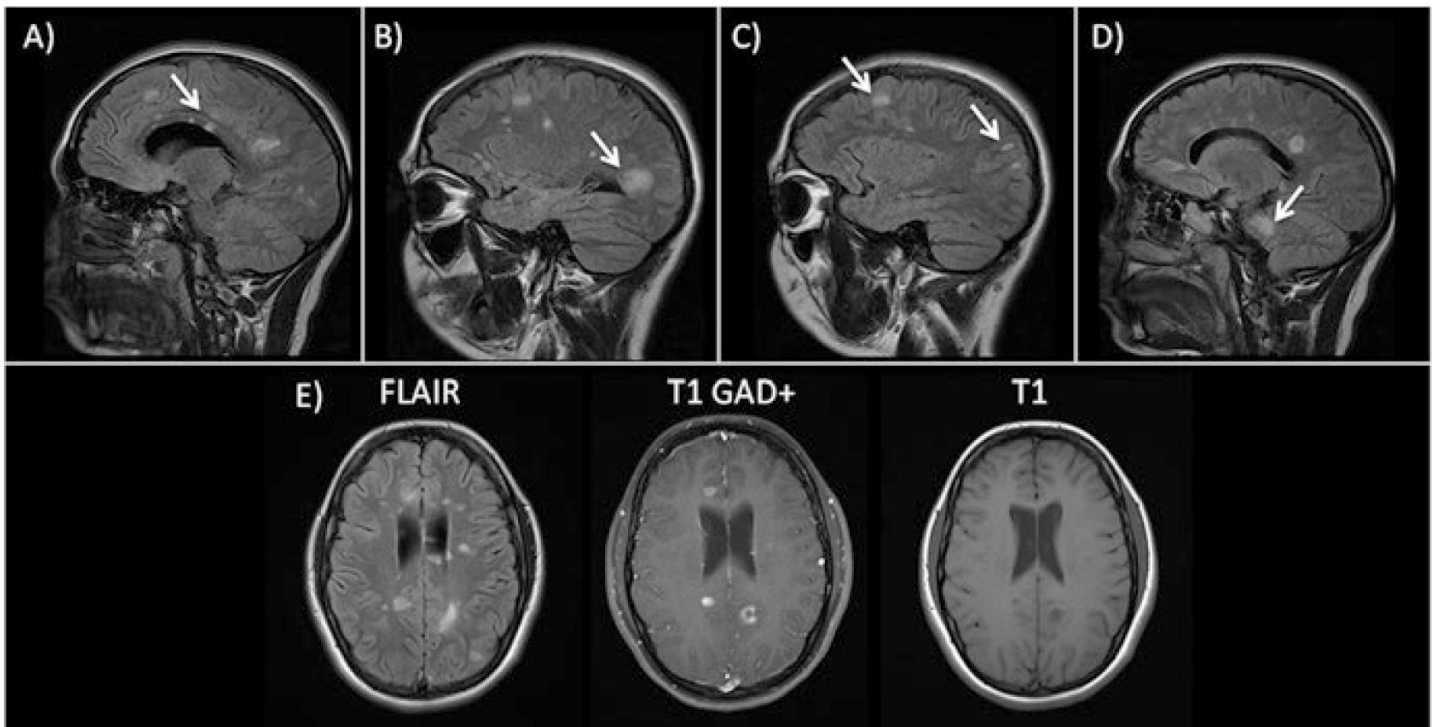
Common lesions in patients with MS by MRI. Sagittal FLAIR (Figures A-D) and axial (Figure E) MRI brain of a patient with lesions disseminated in space and time according to McDonald criteria are shown. Demyelinating lesions are present in regions such as the corpus callosum (Figure A), periventricular region (Figure B), juxtacortical region (Figure C), and infratentorial region (Figure D). Simultaneous contrast-enhanced and non-contrast-enhanced lesions are also present according to the single scan criteria for DIT. Taken from: (Buzzard et al., 2017)
